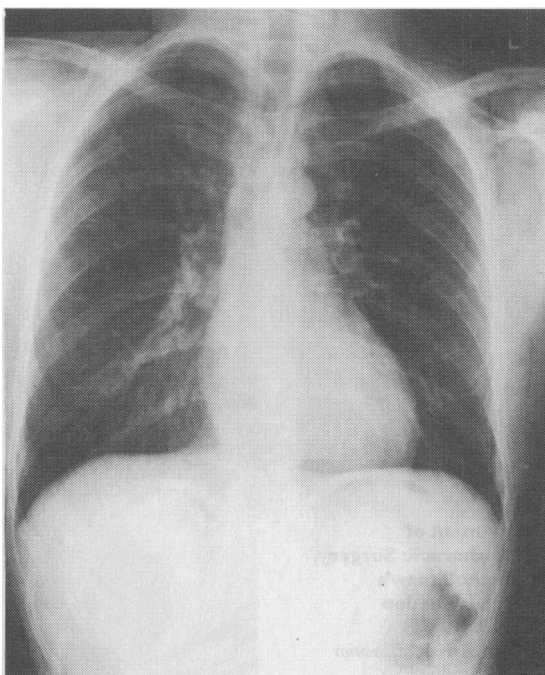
Plain chest radiograph showing widespread subcutaneous and mediastinal emphysema
